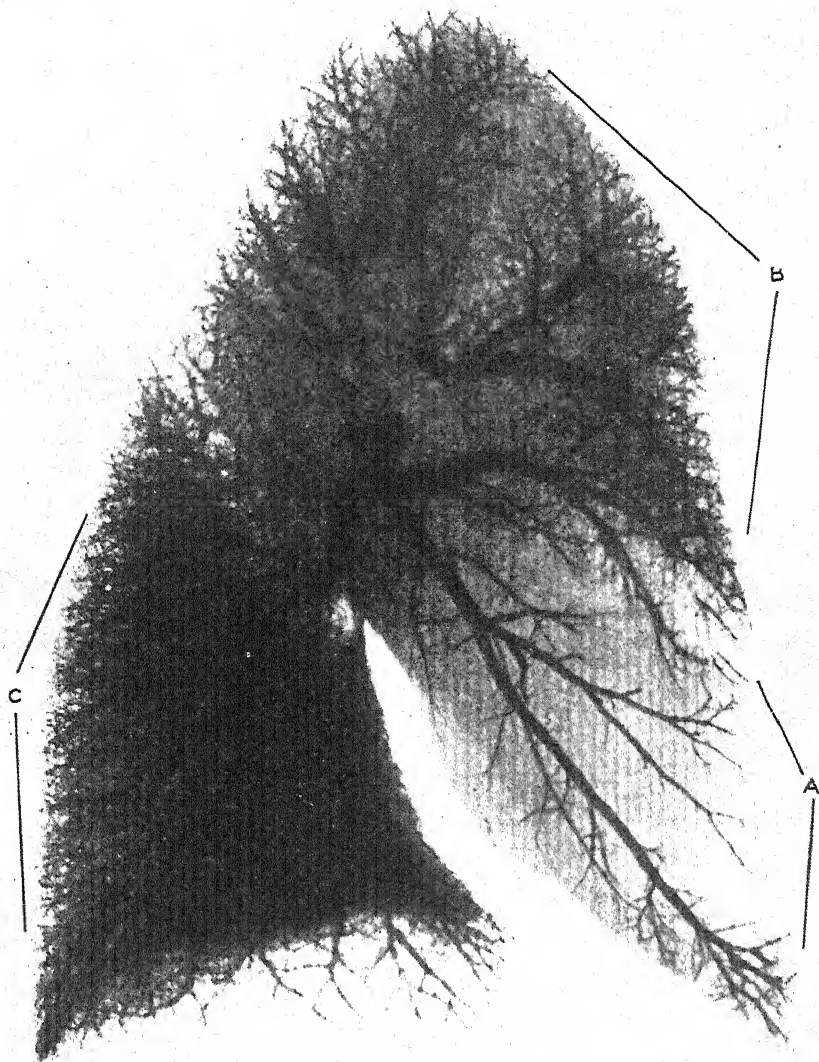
X-ray photograph of barium-injected lung from a case of lobar pneumonia. (*After Gross.*)
